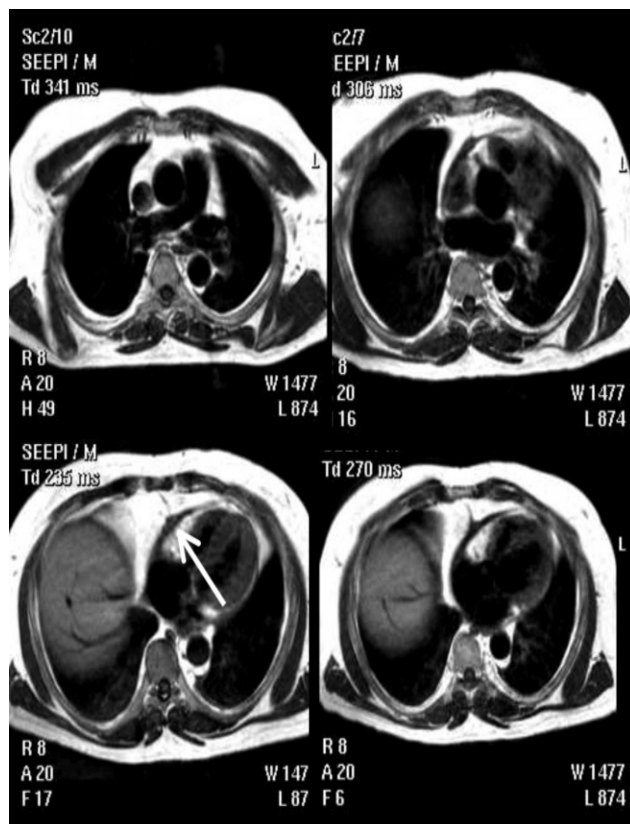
Case: 16-year-old male with ascites being referred to Ochsner for liver transplant. Echocardiogram showed normal left ventricular size and function. Cardiac magnetic resonance imaging: Black blood images. Diagnosis: Pericardial thickening (arrow), resulting in constrictive pericardial disease and hepatic congestion.
